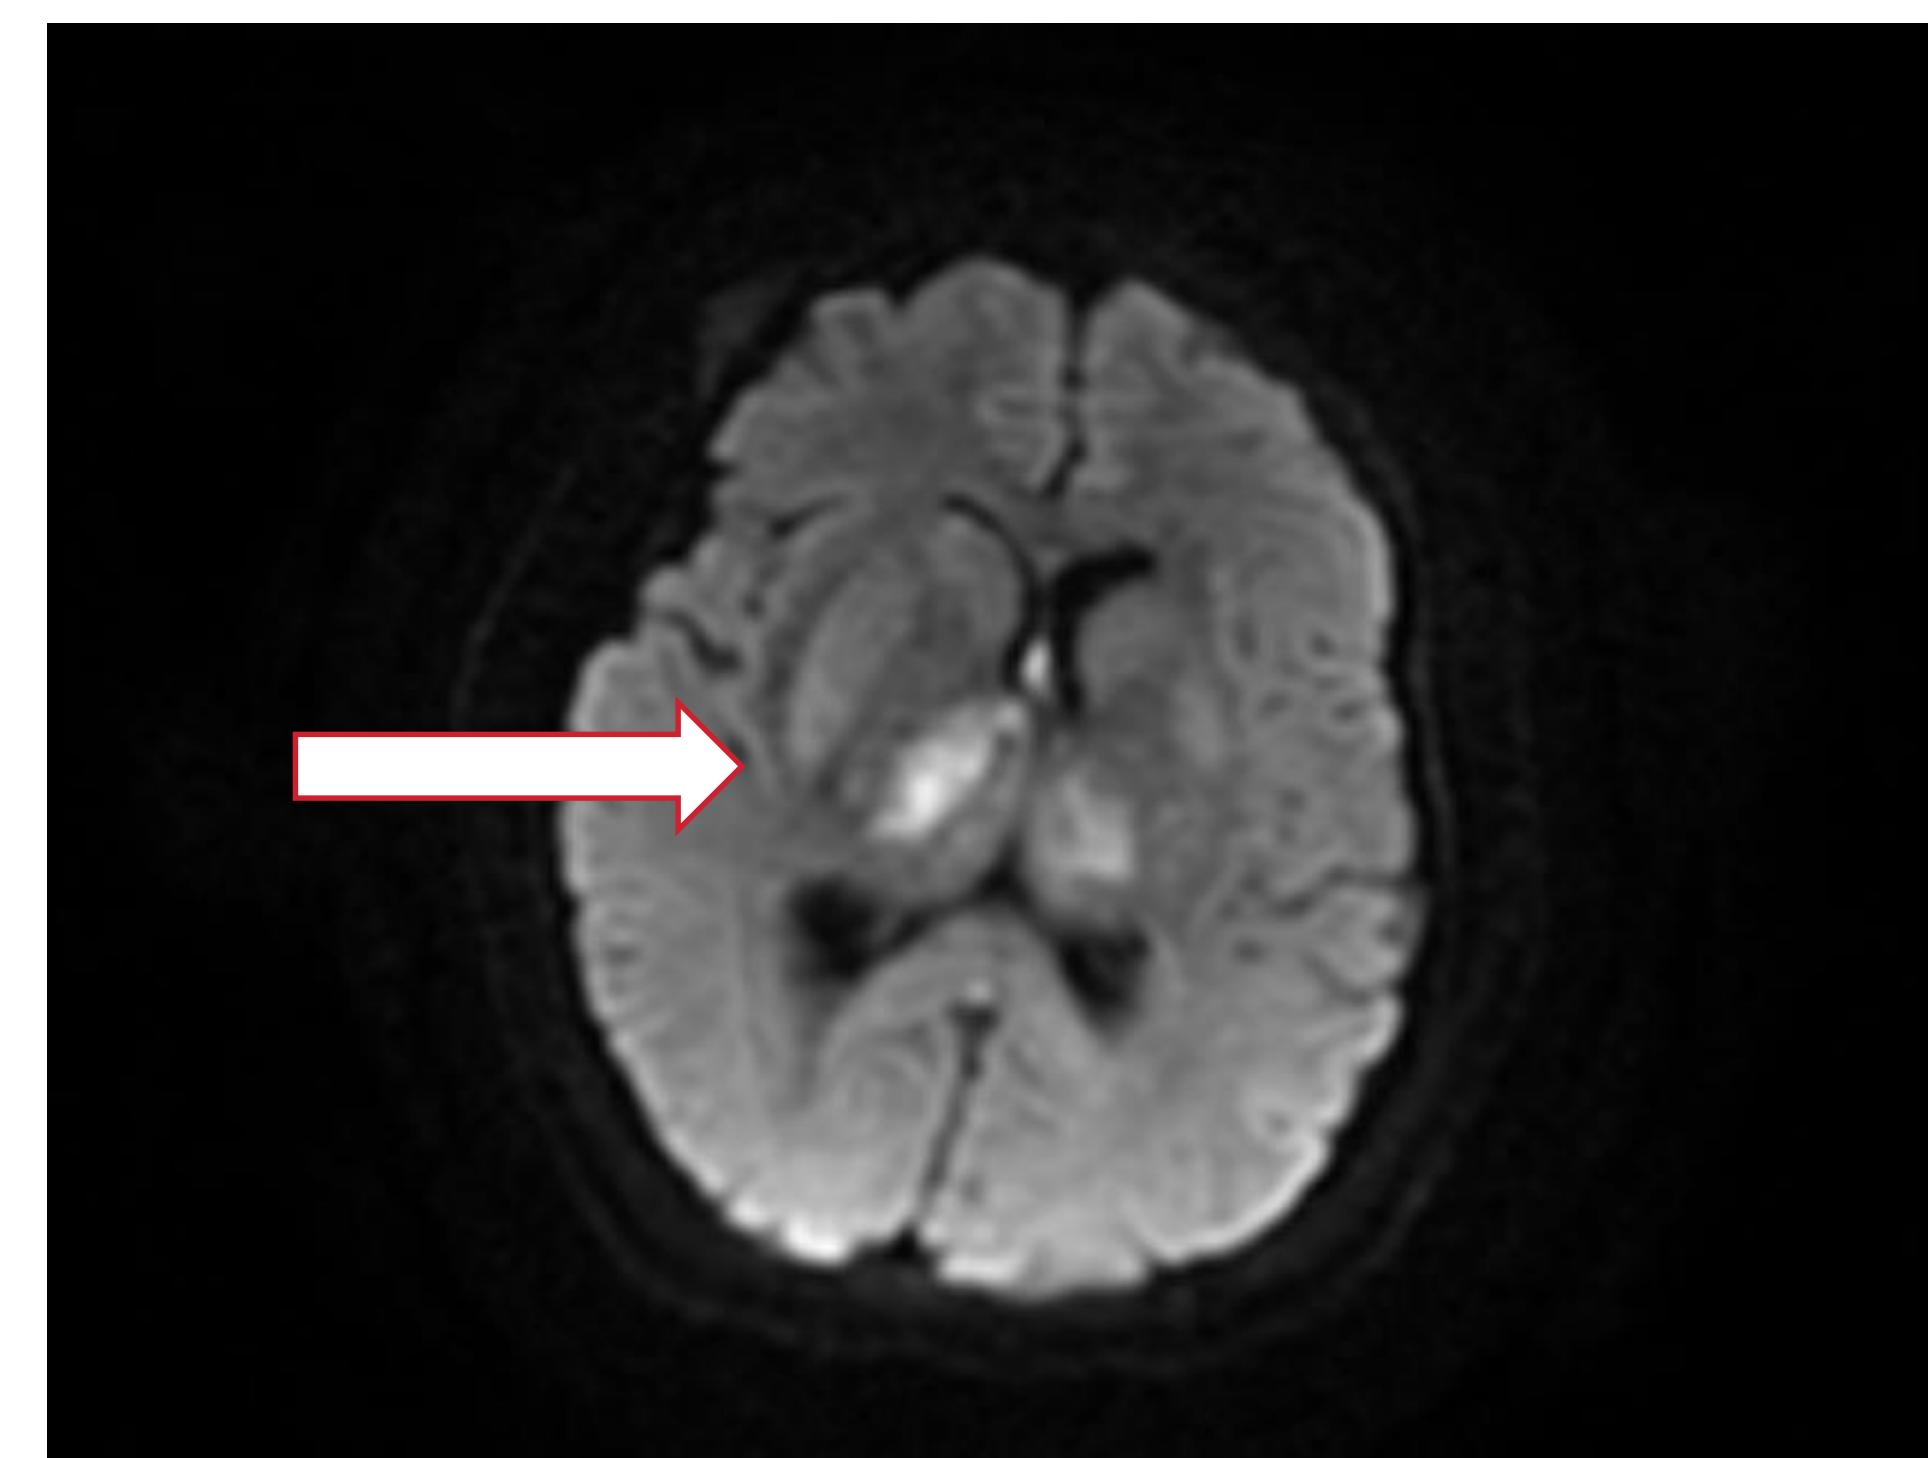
MRI brain with/without contrast revealed secondary venous infarcts of bilateral thalami and right basal ganglia.
